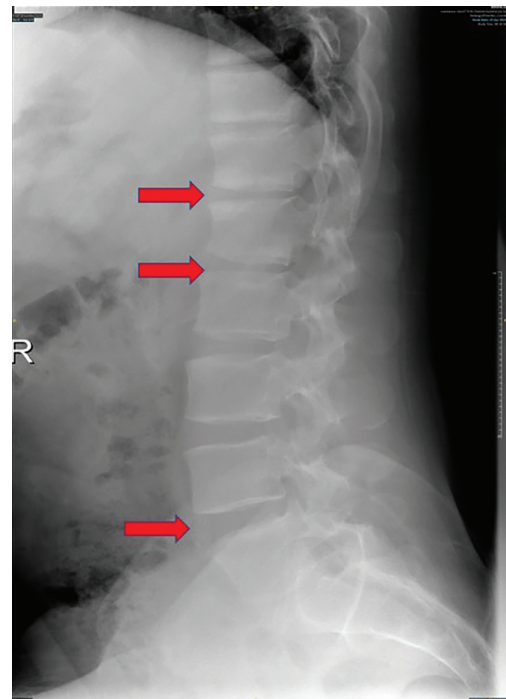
Lateral conventional lumbosacral radiograph. Forty-year-old male patient. Complaints of back pain that increases with movement. CRP: 2 mg/dL. Spondylodiscitis caused by spondyloarthritis. Lumbar MRI: Discal and medullary signal changes compatible with spondylodiscitis are observed in the T12-L1, L1-2, L4-5 discs and adjacent end plates. In addition, there are active corner lesions in the vertebral corners, mostly at the level of L3 and L4 vertebrae in the anterior, and signal changes thought to belong to fatty corner lesions in the posterior. Fatty corner lesions are also observed anteriorly in the L5-S1 end plates. There is no abscess. Culture was not taken. Nine of 11 rheumatologists (82%) recognized spondylodiscitis on conventional radiography
